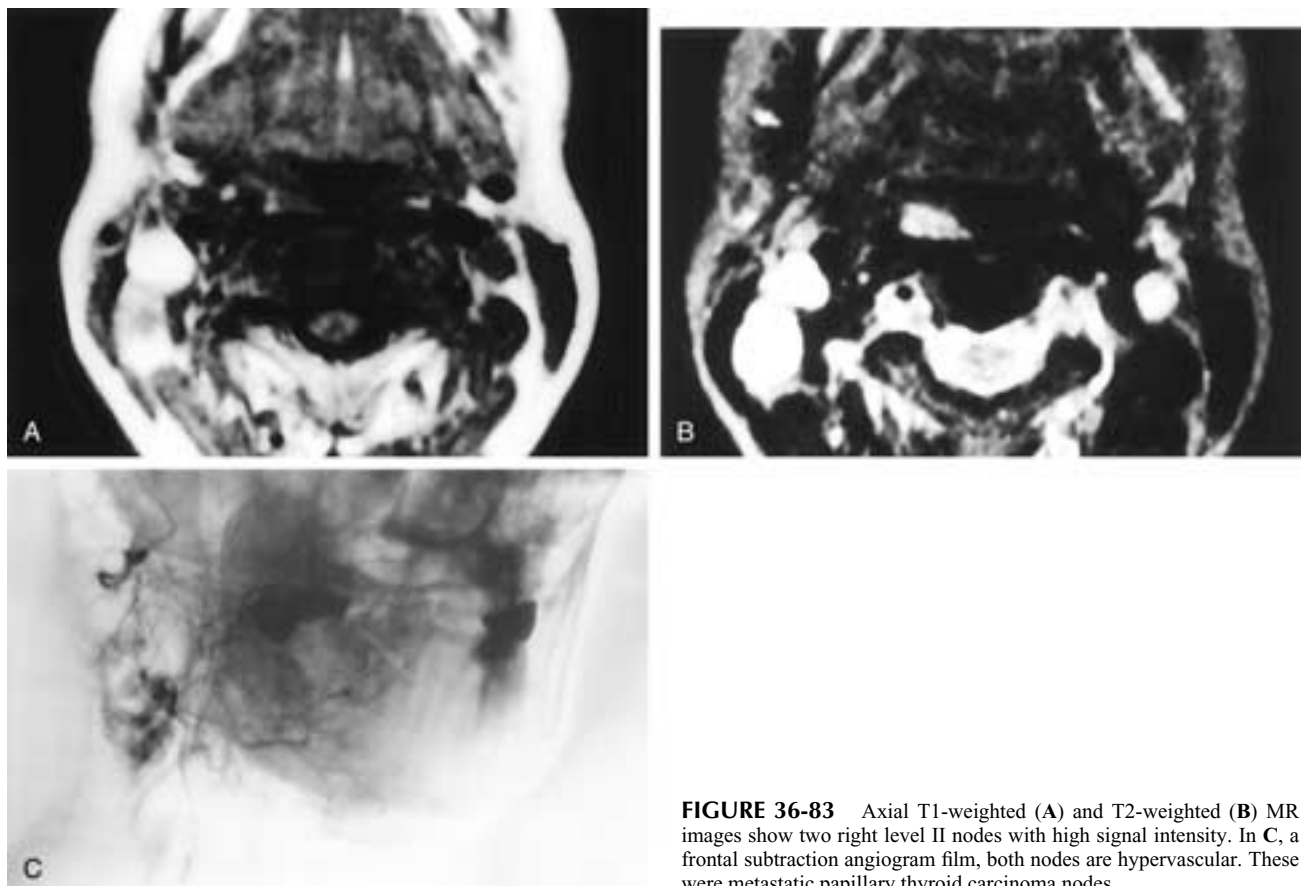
Axial T1-weighted (A) and T2-weighted (B) MR images show two right level II nodes with high signal intensity. In C, a frontal subtraction angiogram film, both nodes are hypervascular. These were metastatic papillary thyroid carcinoma nodes.
